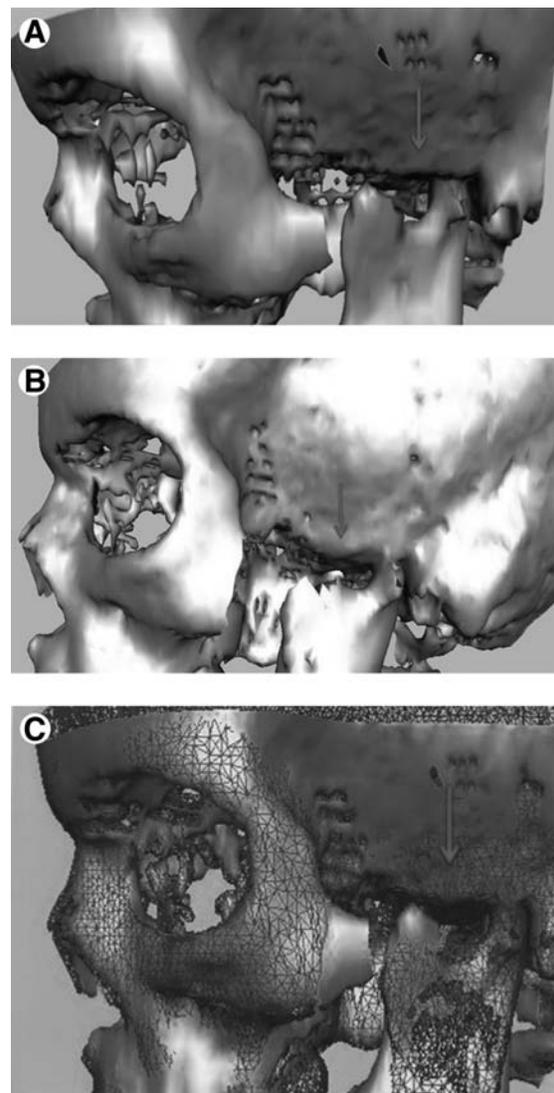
(A) Preoperative 3D CT reconstruction. Note the flat appearance of the squamous part of the temporal bone of the affected joint showing absence of the glenoid fossa and articular eminence. (B) The 3D CT reconstruction after the distraction procedure presents the differences in the morphology of the squamous part of the temporal bone showing a presumptive glenoid fossa and articular eminence. (C) Superimposition of the predistraction (blue, solid model) and postdistraction (red, wire-framed model) using 3D CT reconstructions of the TMJ, localizing the areas of remodeling. Note the formation of a rudimentary, incomplete, glenoid fossa and articular eminence, corroborating the MRI findings reported. (Color version of figure is available online.)
